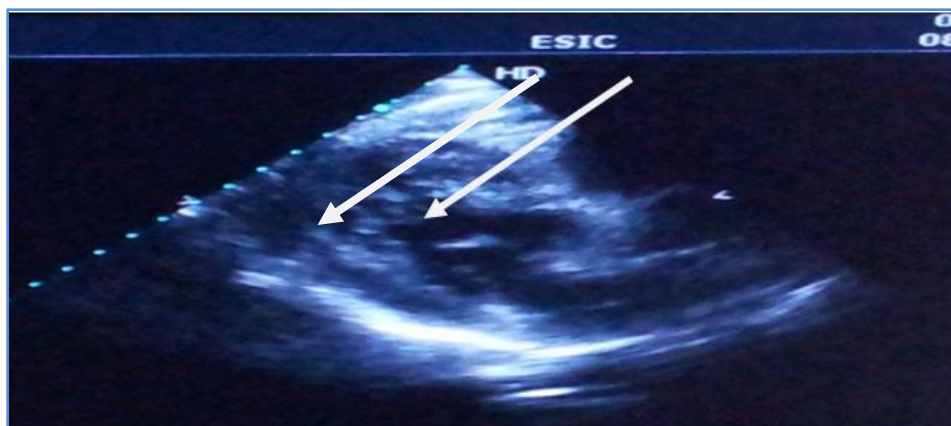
2D Echocardiogram shows sinuses in the left ventricle
